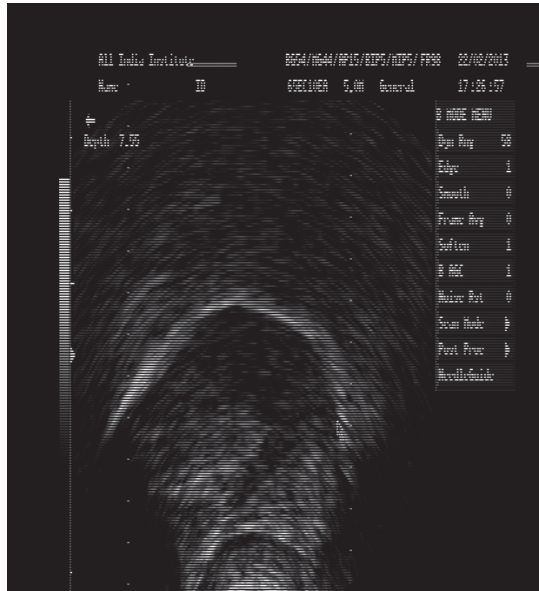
Ultrasound image at the consonant dental /t/ from the word /atta/ produced by a child speaker. Left side of the figure indicates the front of the oral cavity and right side shows back of the oral cavity.
